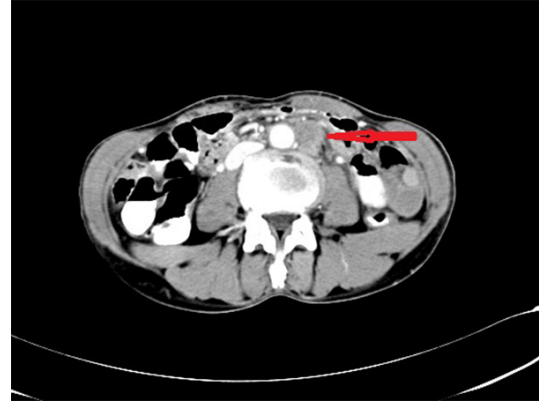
CT test for a patient with cervical cancer in stage IIB. The red arrow is pointing to a para-aortic lymph node.
